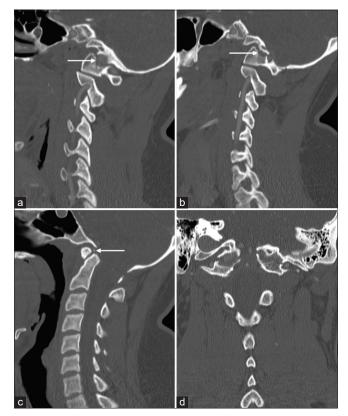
Computed tomography (CT) of the cervical spine in right (a) and left (b) parasagittal planes demonstrates partial atlantooccipital assimilation (AOA), with bilateral fractures causing up to 3 mm of distraction at the craniovertebral junction (arrows). Note that fracture involves the rudimentary left foramen transversarium; no evidence for vascular injury was identified on CT angiography, not shown. A midsagittal plane (c) demonstrates a small avulsion fracture just superior to the odontoid process (arrow). Platybasia and basilar invagination are present. A C1 posterior fusion anomaly is also suggested, but better appreciated on axial images, not shown. The basion-dens interval is mildly widened, but the atlantodental interval is preserved. A coronal reconstruction (d) emphasizes the AOA with superimposed traumatic dissociation of the occiput from the cervical spine.
